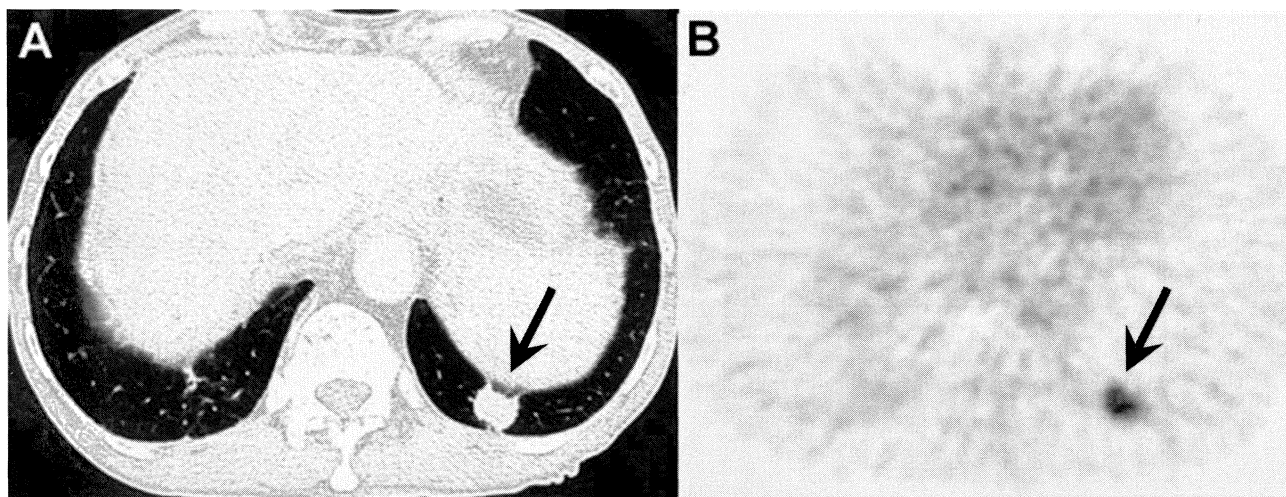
HRCT上solid patternでFDG高集積度を呈した肺腺癌症例
